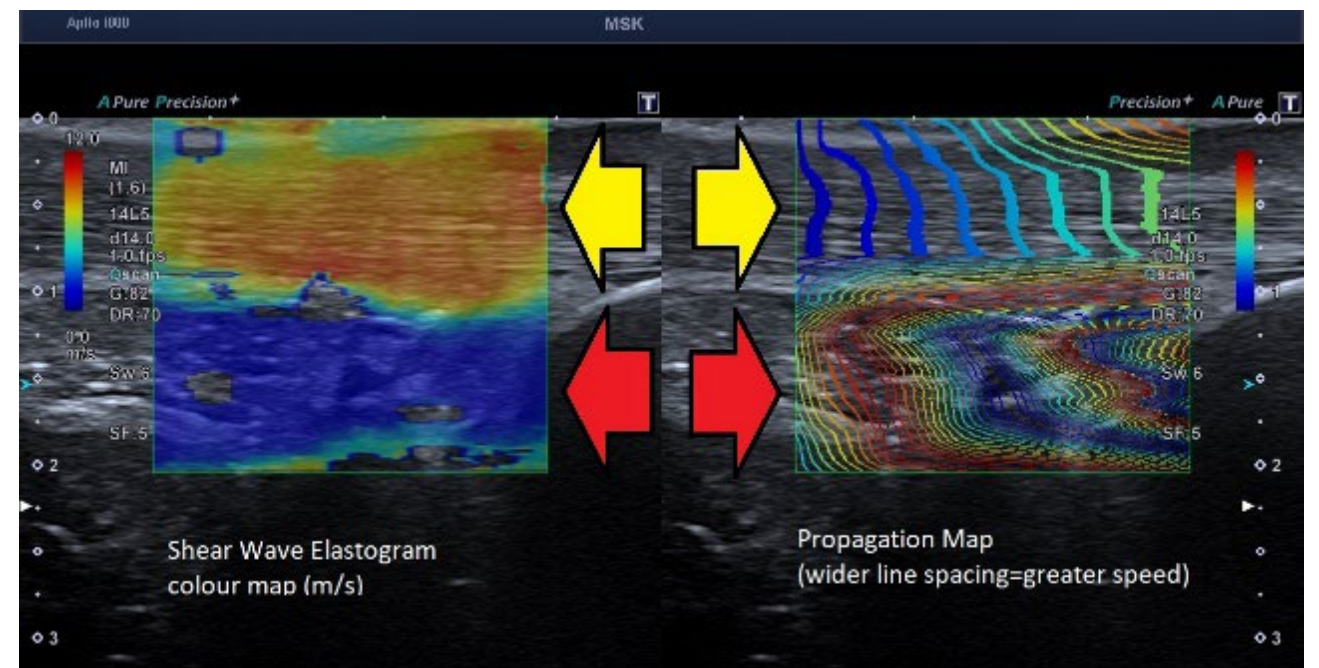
Ultrasound shear wave elastogram image of the Achilles tendon
